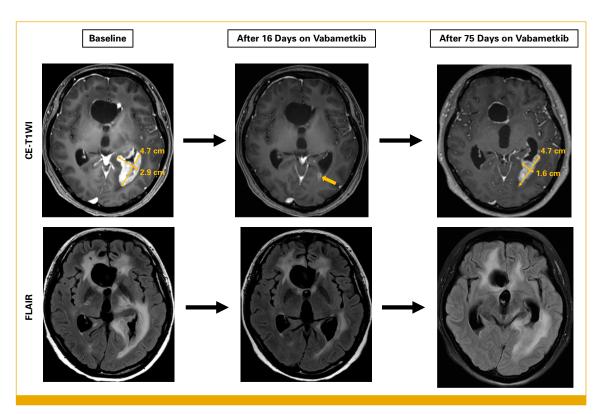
Tumor response according to RANO criteria. The MRIs show a partial response (as defined by RANO criteria) 16 days after vabametkib treatment and disease progression after 75 days. FLAIR, fluid-attenuated inversion recovery; MRI, magnetic resonance imaging; RANO, response assessment in neuro-oncology.
